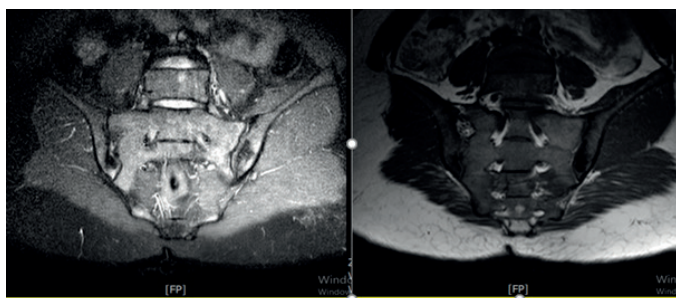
The patient's sacroiliac magnetic resonance images weighted respectively by T2 and T1
